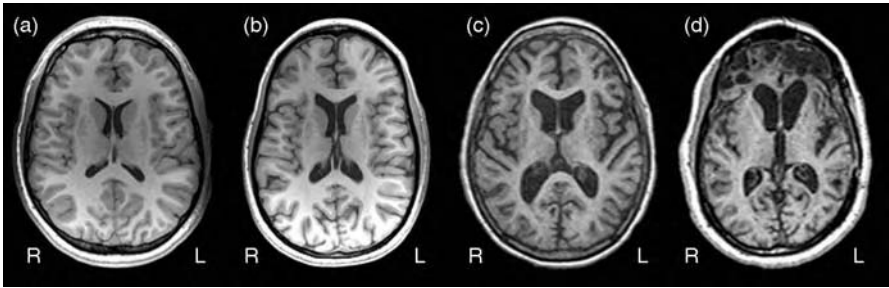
Magnetic resonance imaging (MRI) atrophy ratings in child traumatic brain injury (TBI). All images are T1-weighted MRIs in the axial plane at the level of the anterior horns of the lateral ventricles and have been taken from child/adolescent individuals between 10 and 17 years of age. (a) Normal appearance of ventricles and cortical sulci. (b) Mild atrophy – note the ventricle is slightly larger, sulci more prominent, particularly the interhemispheric fissure. (c) Moderate atrophy – note the increased and widespread cortical and intra-sulcal cerebral spinal fluid (CSF) as well as the prominence of the interhemispheric fissure. (d) Severe atrophy – note in addition to the ventricular dilation, there is widespread encephalomalacia and wasting of the frontal lobe, with prominence of the Sylvian fissure. Typically, the more severe the atrophy the greater the impairment in neuropsychological function.
